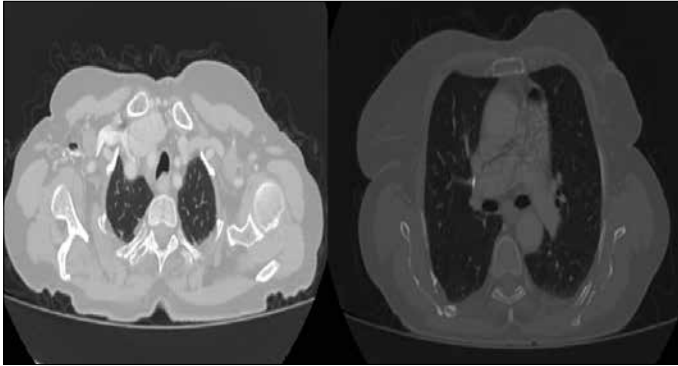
Axial thoracic CT cross sections
